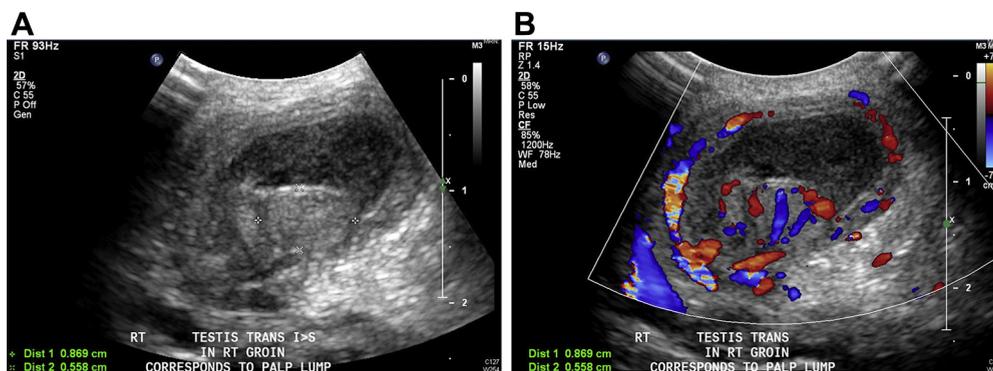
Ultrasound of the testis showing A) a normal sized testis surrounded by an echogenic fluid collection, and B) Hyperemia of the tunica and testis demonstrated by color Doppler.
